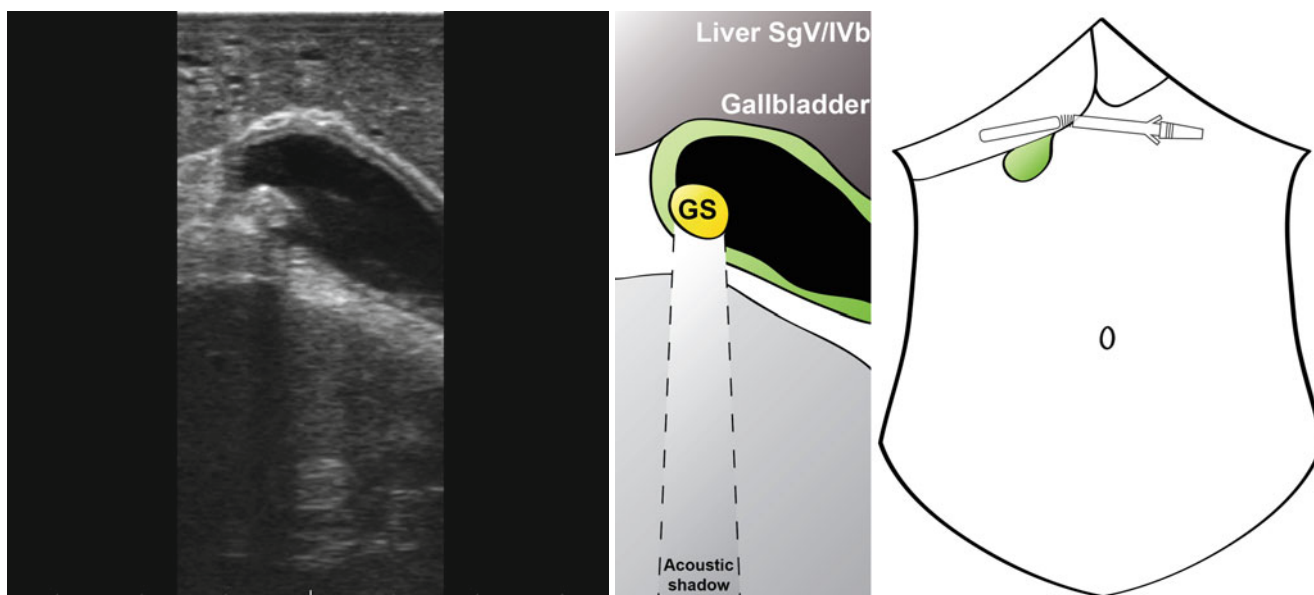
Laparoscopic ultrasound in the assessment of the gallbladder. In this patient, a suspicious polyp was reported on preoperative imaging. On LUS, only a simple gallstone (GS) is seen in the gallbladder, with no wall thickening or infiltrating lesion
